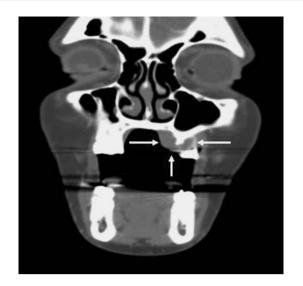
Computed tomography (coronal view) of the maxillofacial area shows a soft tissue mass involving the left hard palate with erosion of the maxillary cortex (Case 3)
